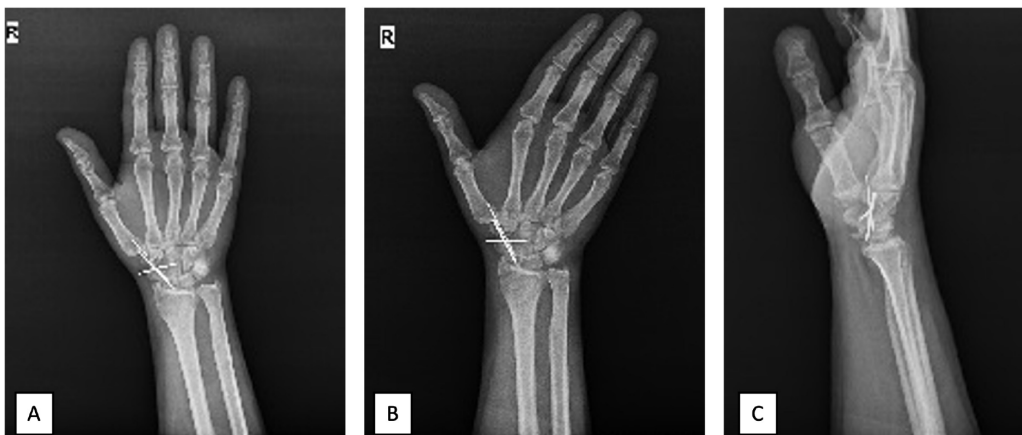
Early postoperative radiographs of the patient who was operated for non-union in the proximal 1/3 of the scaphoid bone. Fixation with K-wire between the scaphoid fracture ends and in the scapocapitate joint A) AP X-ray, B) AP X-ray in ulnar deviation, C) Lateral X-ray
